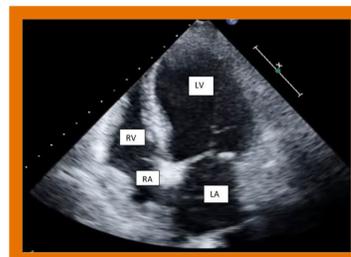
shown to the right, demonstrates the typical echocardiogram findings in Takotsubo cardiomyopathy. In a video form, one would see diffuse hypokinesis in the left ventricle.
